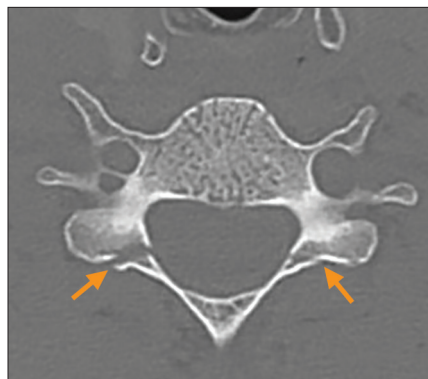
Axial computed tomography image demonstrating bilateral C6 lamina fractures.
